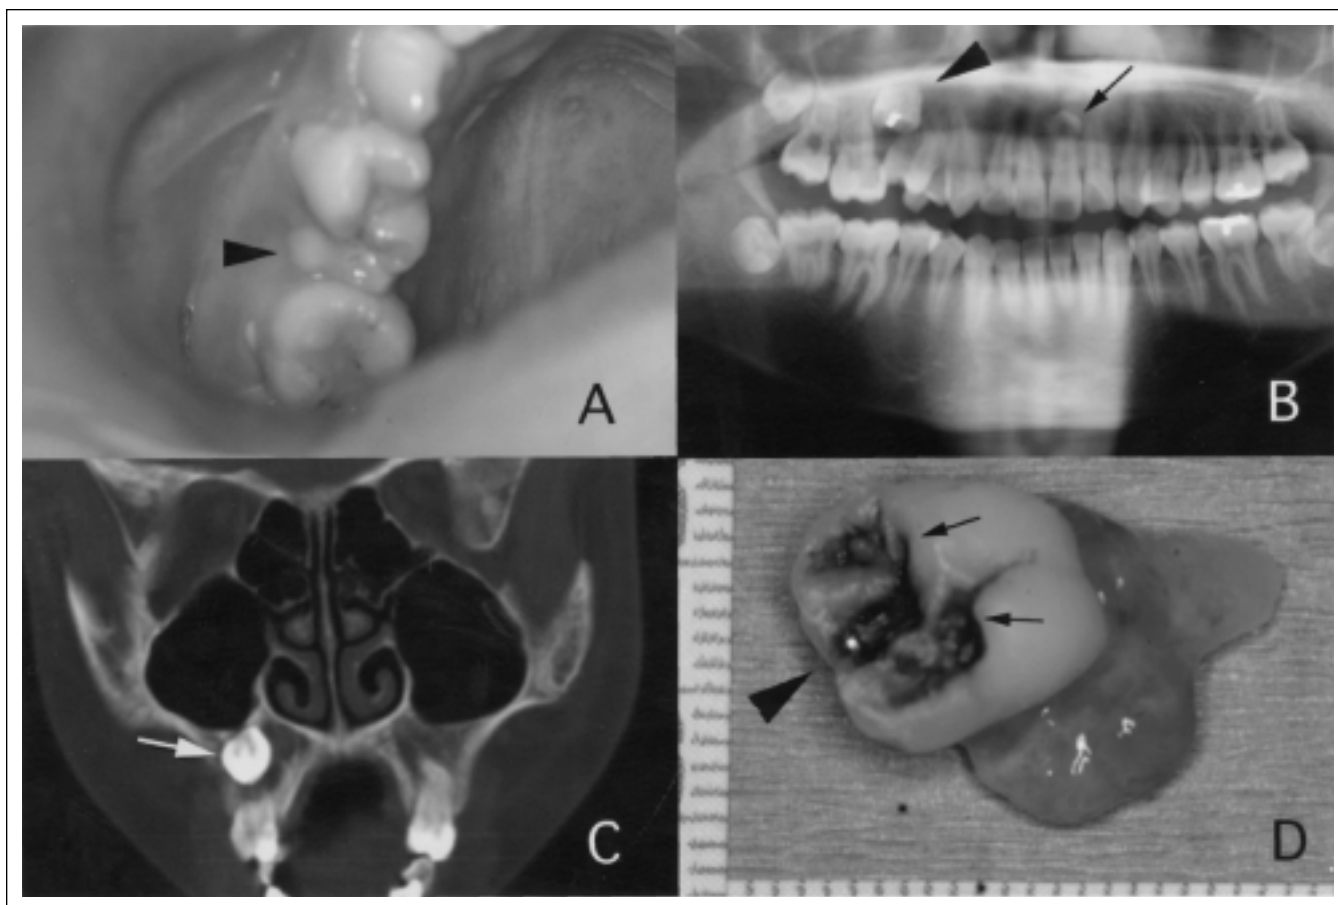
Case 2. A: Intra-oral findings. Right second premolar (□) was erupted, and a submerged tooth was found. B: Orthopantomogram view. The arrowhead indicates the impacted tooth with metal material. The arrow shows the supernumerary tooth. C: CT findings. The impacted tooth (□) was found in maxilla. D: Enucleated material. Surrounding soft tissue adhered in the tooth root. The arrowhead indicates the amalgam filling. The arrow shows the dental caries.
